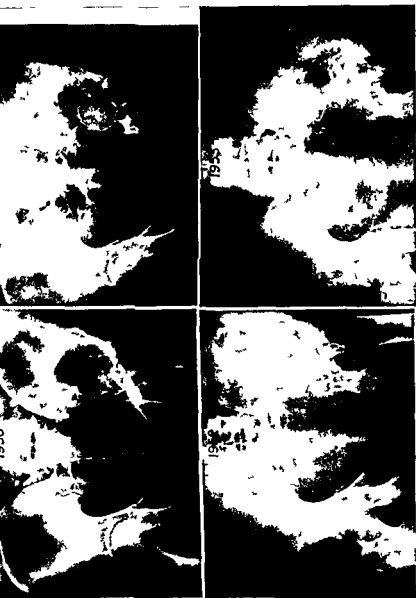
Serial roentgenograms showing metastases to the left pelvis arising from thyroid carcinoma. The patient was seen for the first time in 1941 and died in 1953. This series demonstrates the progression of the lesion from venous extension excepting 1946 and 1951. In 1944 the metastasis was found in the left ilium. A gradual inferior extension of the disease noted to involve the pubis and ischial bones. With the advancement of the disease, the head of the femur is seen to erode through the acetabulum. Clinically the patient became a gradual cripple as the process advanced. She finally was completely bedridden until her death.
